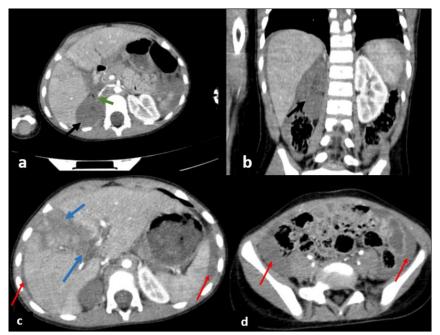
Contrast-enhanced CT findings of traumatic hepatic and renovascular injuries
